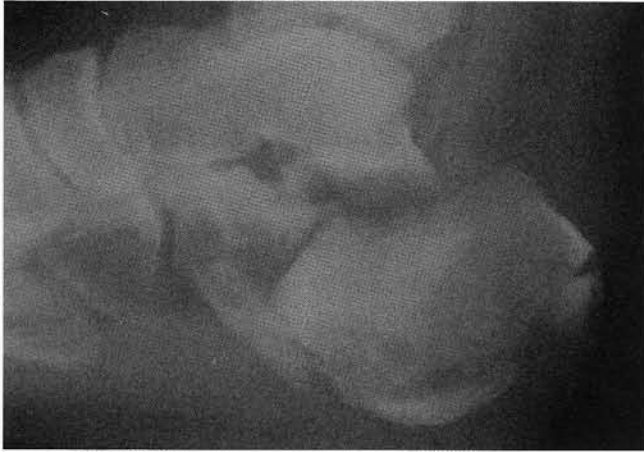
Initial preoperative lateral radiograph.
